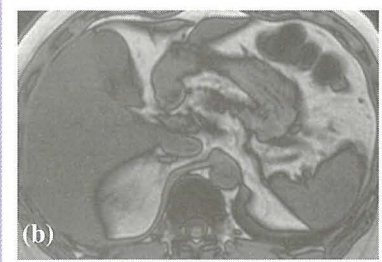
T1-weighted GRE MR images of a fatty liver show a bright parenchymal signal on the in-phase image (a) and marked decrease in the signal intensity of the liver on the opposed-phase image (b).
